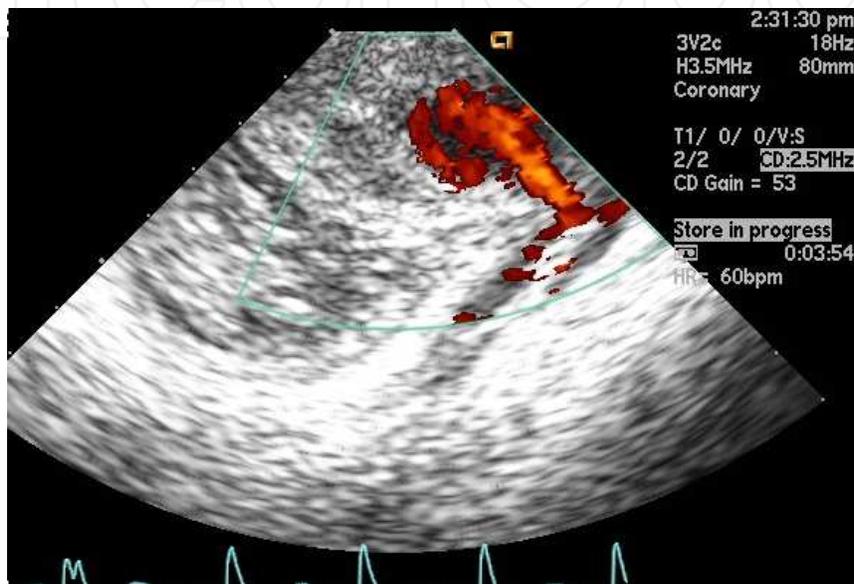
Doppler ultrasonography image showing a flow jet from superficial femoral artery to pseudoaneurysm surrounded by huge hematoma
